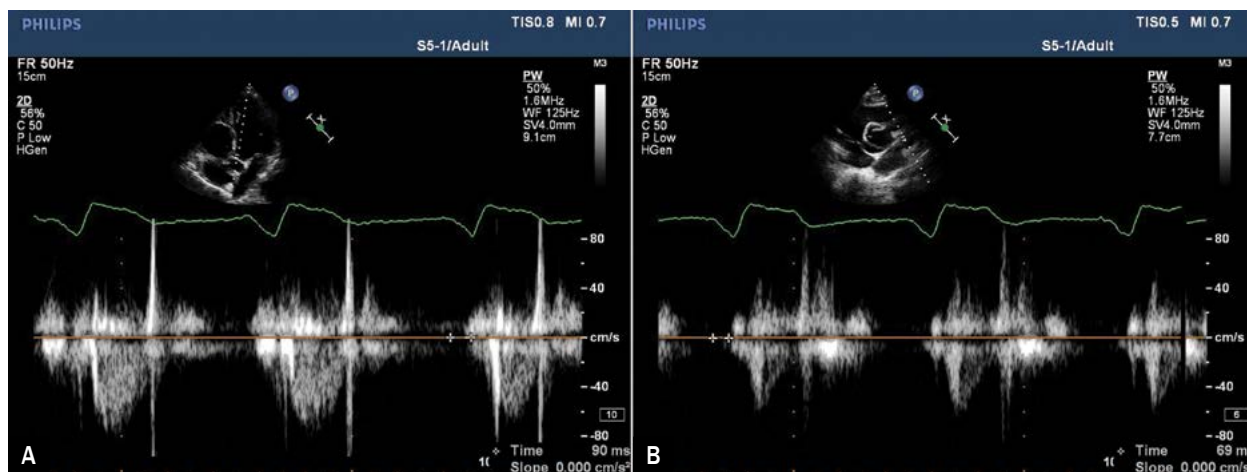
Calculation of pre-ejection period as time interval from onset of QRS complex to the onset of pulse-Doppler velocity curve: A. Left ventricular pre-ejection periods (LVPEP); B. Right ventricular pre-ejection periods (RVPEP)
